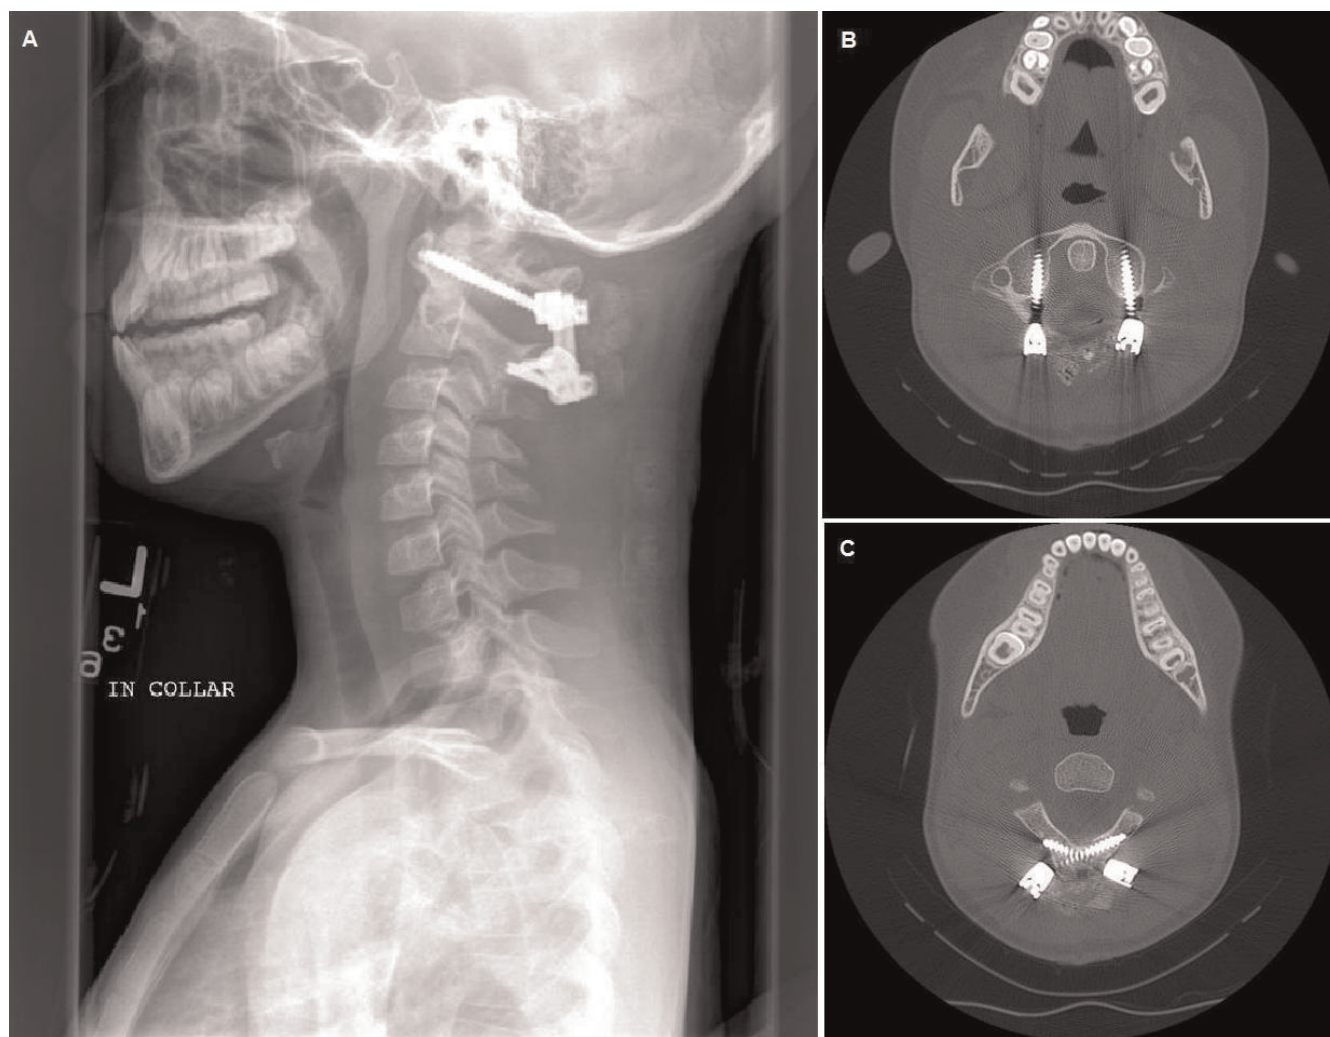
(A) Postop lateral cervical spine X-ray and axial CT of the cervical spine shows (B) C1 lateral mass screws and (C) bilateral crossing C2 translamina screws.
